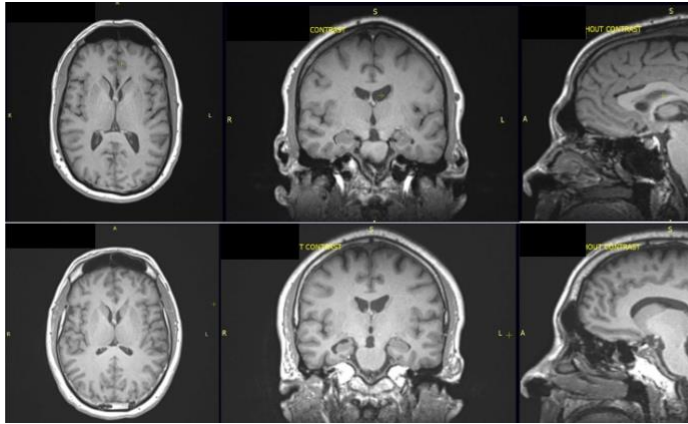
MRI Scans of Injured and Healthy Subjects
